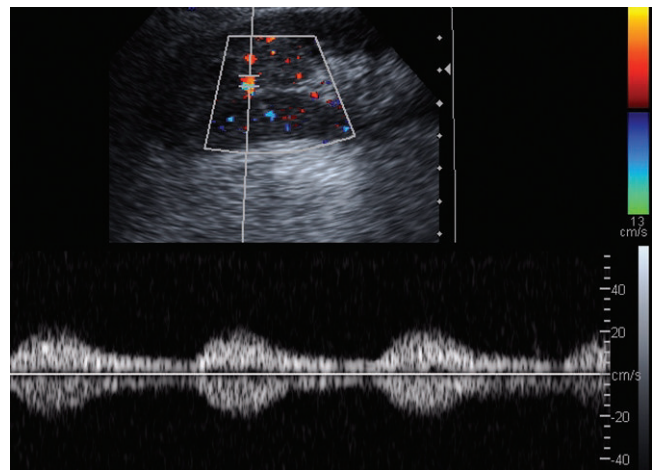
The Doppler waveform was obtained in an upper pole segmental renal transplant artery branch and has a tardus parvus appearance indicative of a more proximal stenosis.
